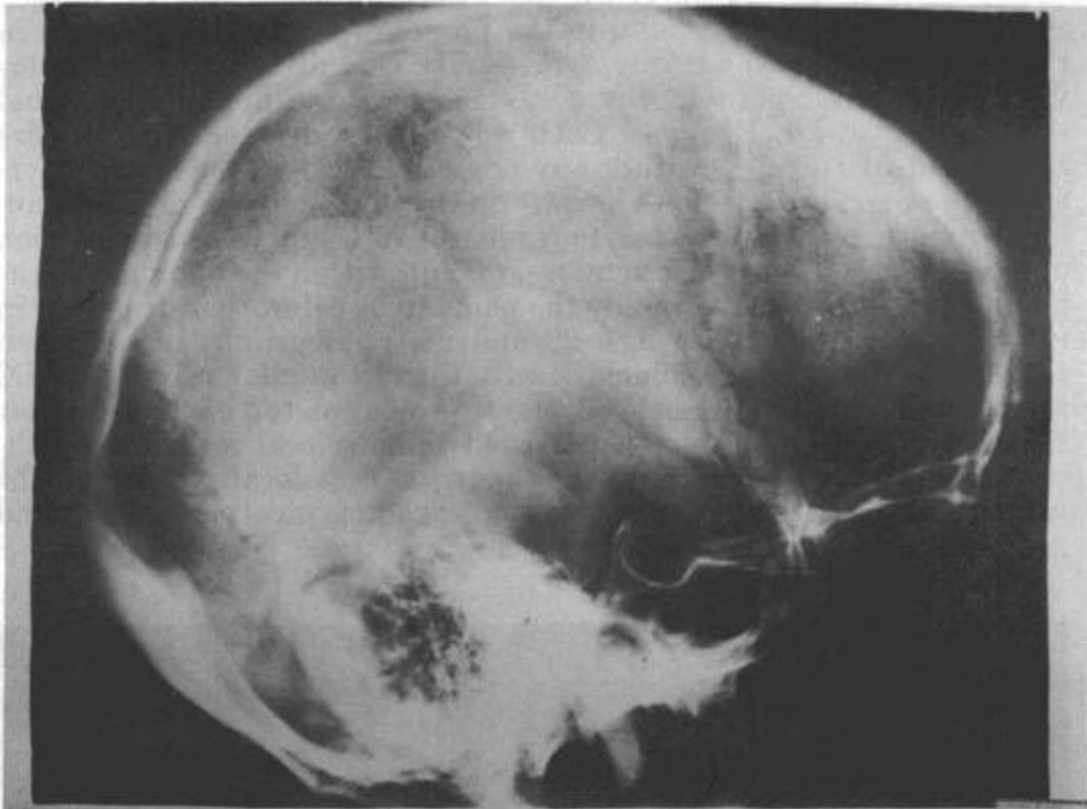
Photograph of a pre-mortem lateral X-ray of the skull of President John F. Kennedy, against which to compare the damage shown in the autopsy X-rays Nos. 1 and 2.
